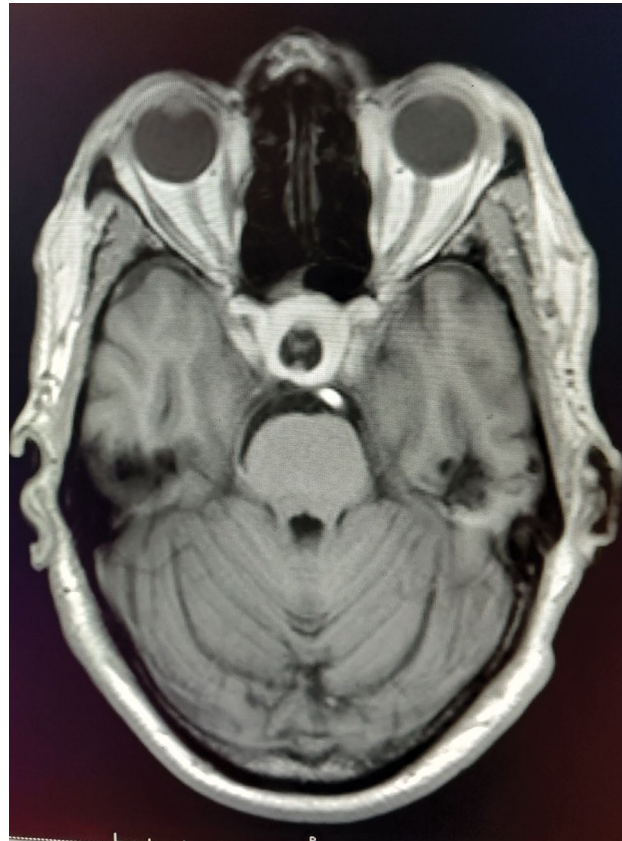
Fat-like T1 hyperintensity was detected in postoperative MRI at 5 months.
